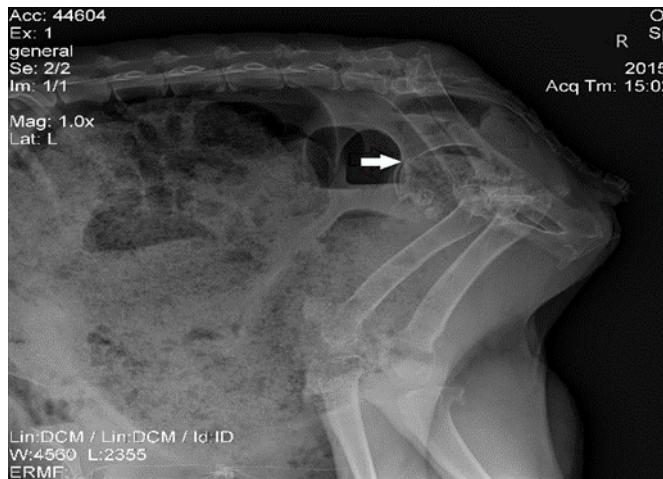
Radiograph of abdomen of doe on day after surgery; note the fetal head (white arrow) in the pelvic vagina.
